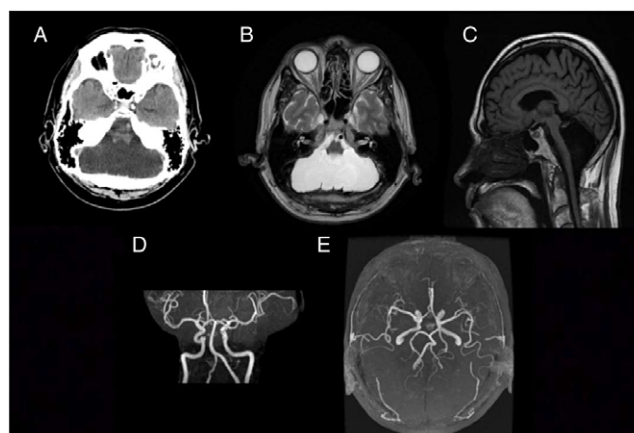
(a) CT showing complete absence of cerebellar tissue, thinning of brainstem, absent of cerebellar peduncles. (b) and (c) MRI confirming complete cerebellar agenesis, pontine atrophy and small midbrain. (d) and (e) MR angiography demonstrating absence of any cerebellar arteries.
